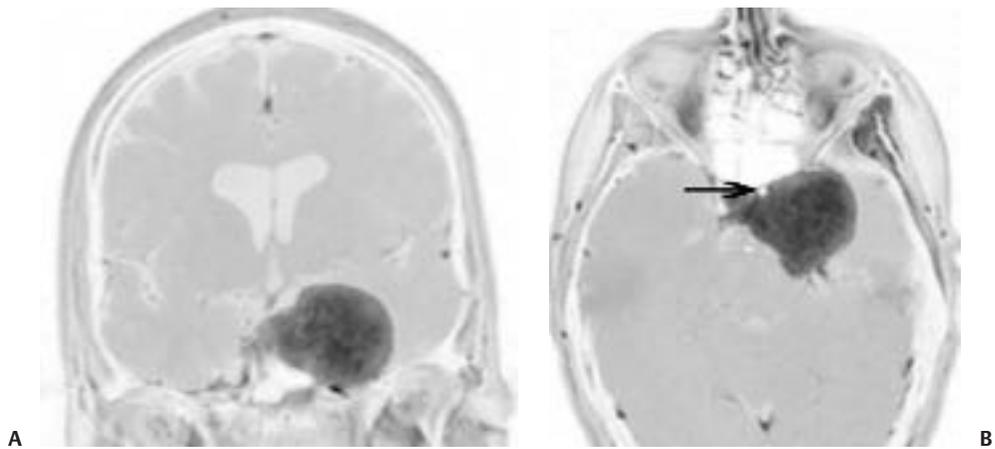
Meningioma mimics. (A) Coronal T1 and (B) axial T1 postcontrast views demonstrate a left parasellar and sellar intensely enhancing mass proven to be a hemangiopericytoma. Note anterior displacement of the left internal carotid artery (*arrow* in [B]). (C,D) A different patient, with a mass within the right cavernous sinus demonstrating (C) high signal intensity on T2-weighted sequences and (D) marked and homogeneous contrast enhancement. This was a proven cavernous sinus hemangioma.
